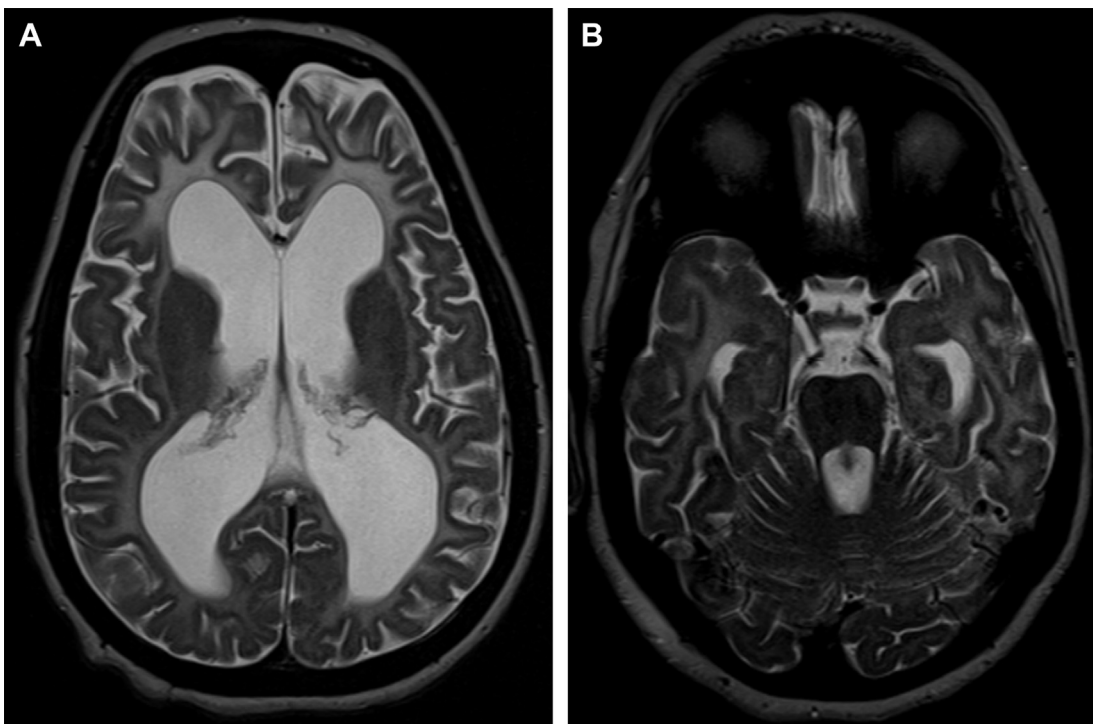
14-year-old boy with TTD. (A) and (B) Axial T2-weighted images show diffuse abnormal T2-hyperintense signal of the supratentorial white matter, ventriculomegaly, and cerebellar atrophy.
